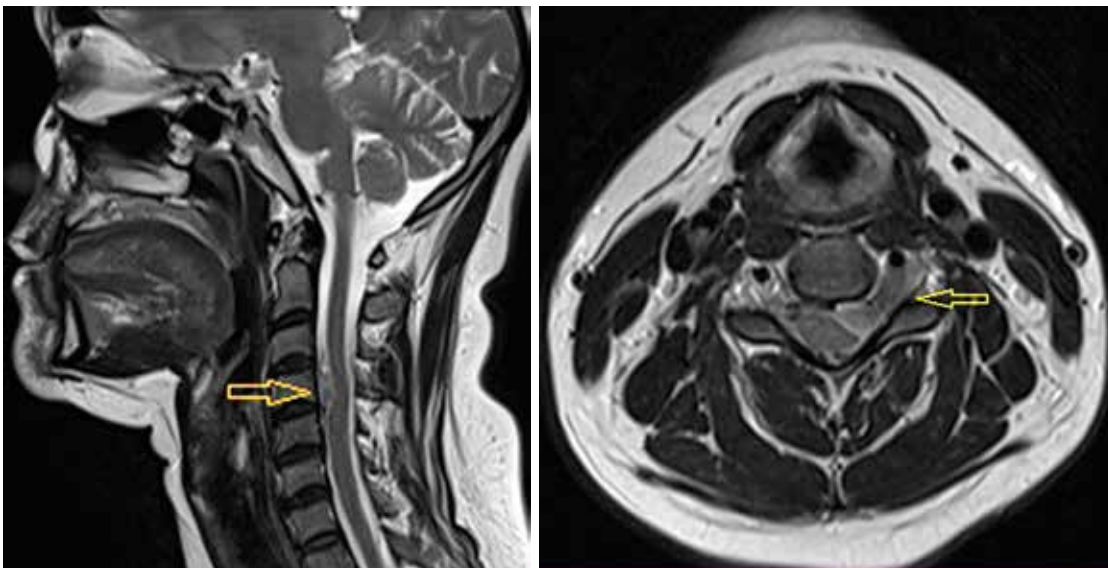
MRI of the cervical spine with contrast in T2-mode. The arrow indicates an intra-extravertebral tumor extending through the intervertebral foramen. Tumor size: 13.0×22.0×8.5 mm
